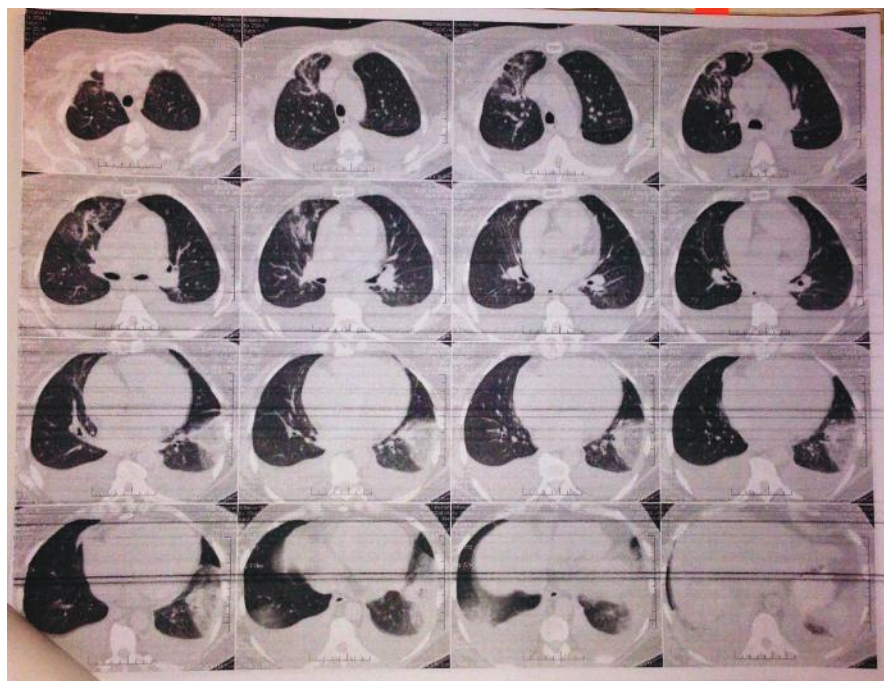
Computed tomography scan of the chest of a patient with chemotherapy-induced cardiomyopathy demonstrating pulmonary infarction.
